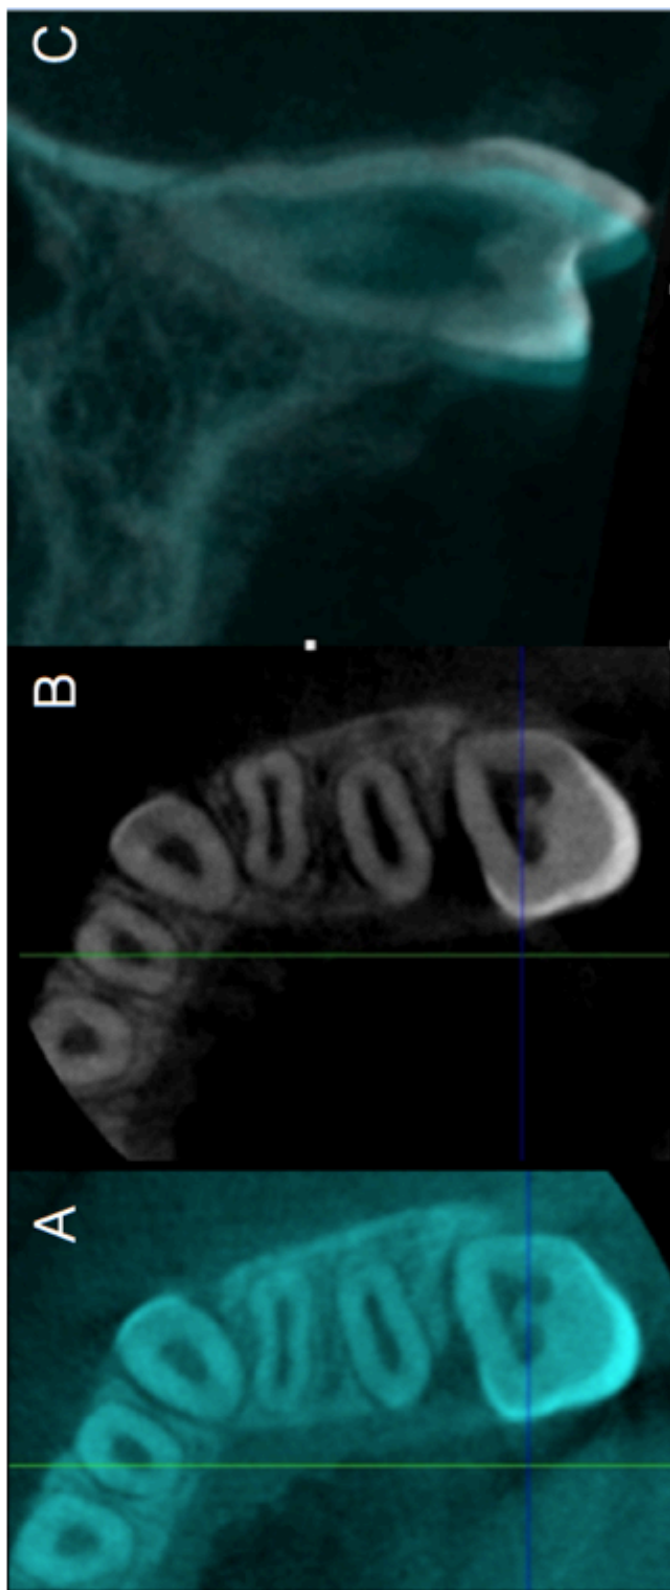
Images from the 3D CBCT superimpositions of patient 12: Patient 12 represents one of the patients with a substantial amount of tooth movement. White is the final position and green is initial. A. Coronal view of superimposed 3D CBCT images. B. Frontal view of superimposed 3D CBCT images.
